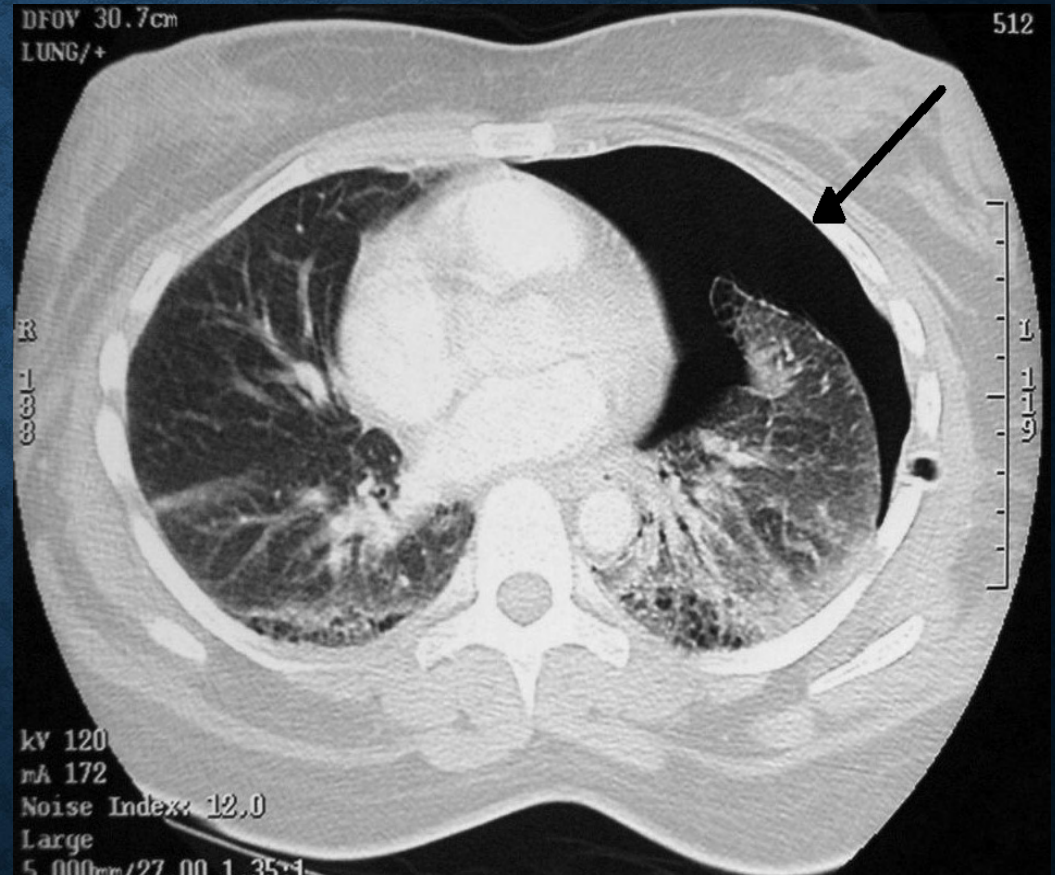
Unenhanced axial chest CT image of a 71-year-old male with congestive heart failure
